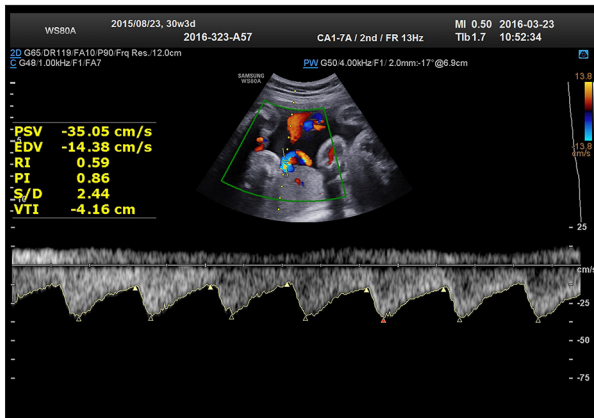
Ultrasound Doppler spectrum of fetal UA in the control group.
